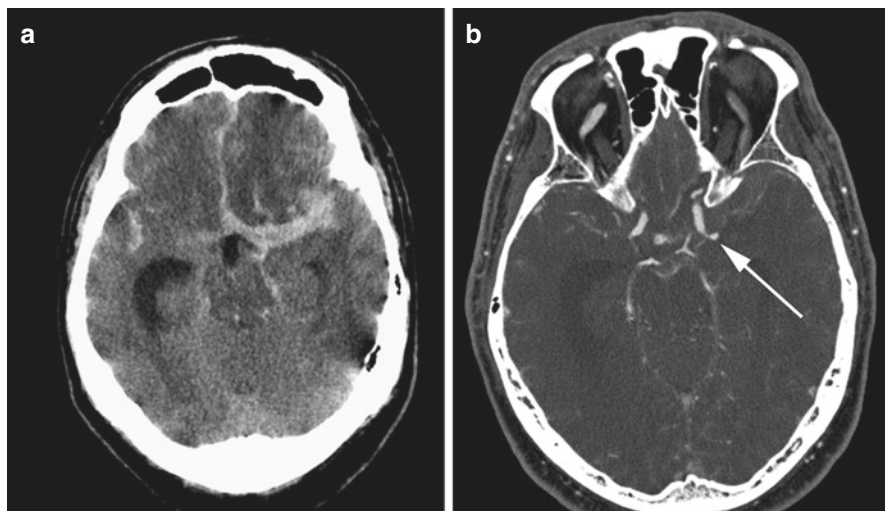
Anterior choroidal aneurysm. Patient presenting with acute subarachnoid hemorrhage asymmetric to the left on noncontrast CT (a). CTA (b) showed a recently ruptured anterior choroidal artery aneurysm (arrow)
